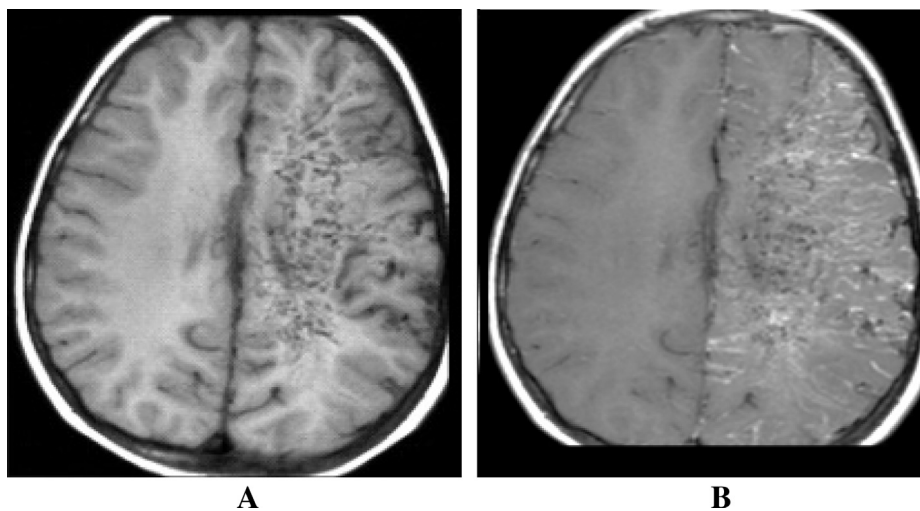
MRI axial T1w sequence with (A) and without (B) contrast showing extensive left parietal intraaxial vascular collaterals secondary to left internal carotid ischemia (moyamoya).
